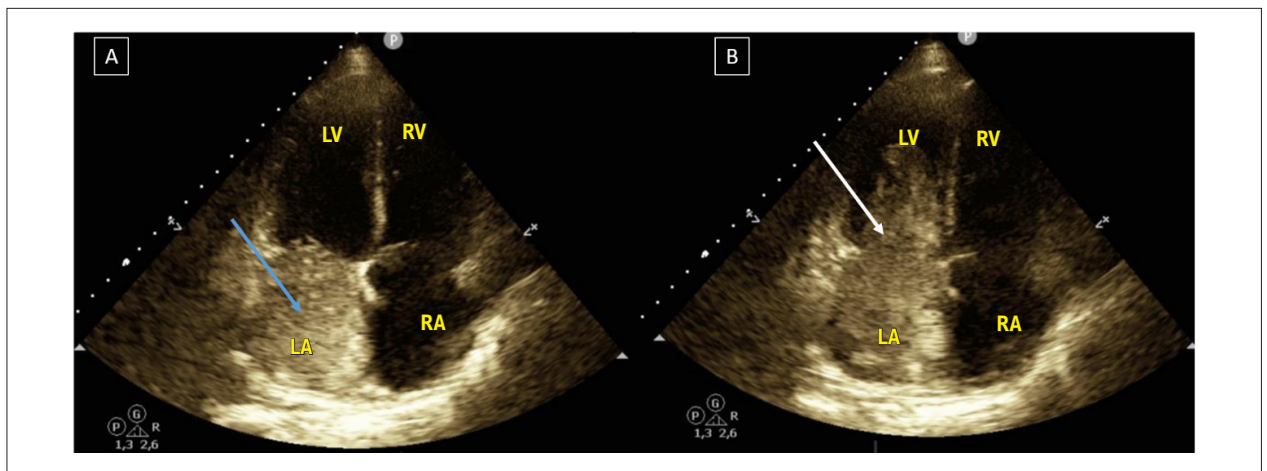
Transthoracic echocardiography in apical 4-chamber view. (A) Image suggestive of a mass in the left atrium (white arrow); (B) Image of the same mass projecting into the mitral valve orifice during diastole and occupying the left ventricle (blue arrow). LA: left atrium; LV: left ventricle; RA: right atrium; RV: right ventricle.
